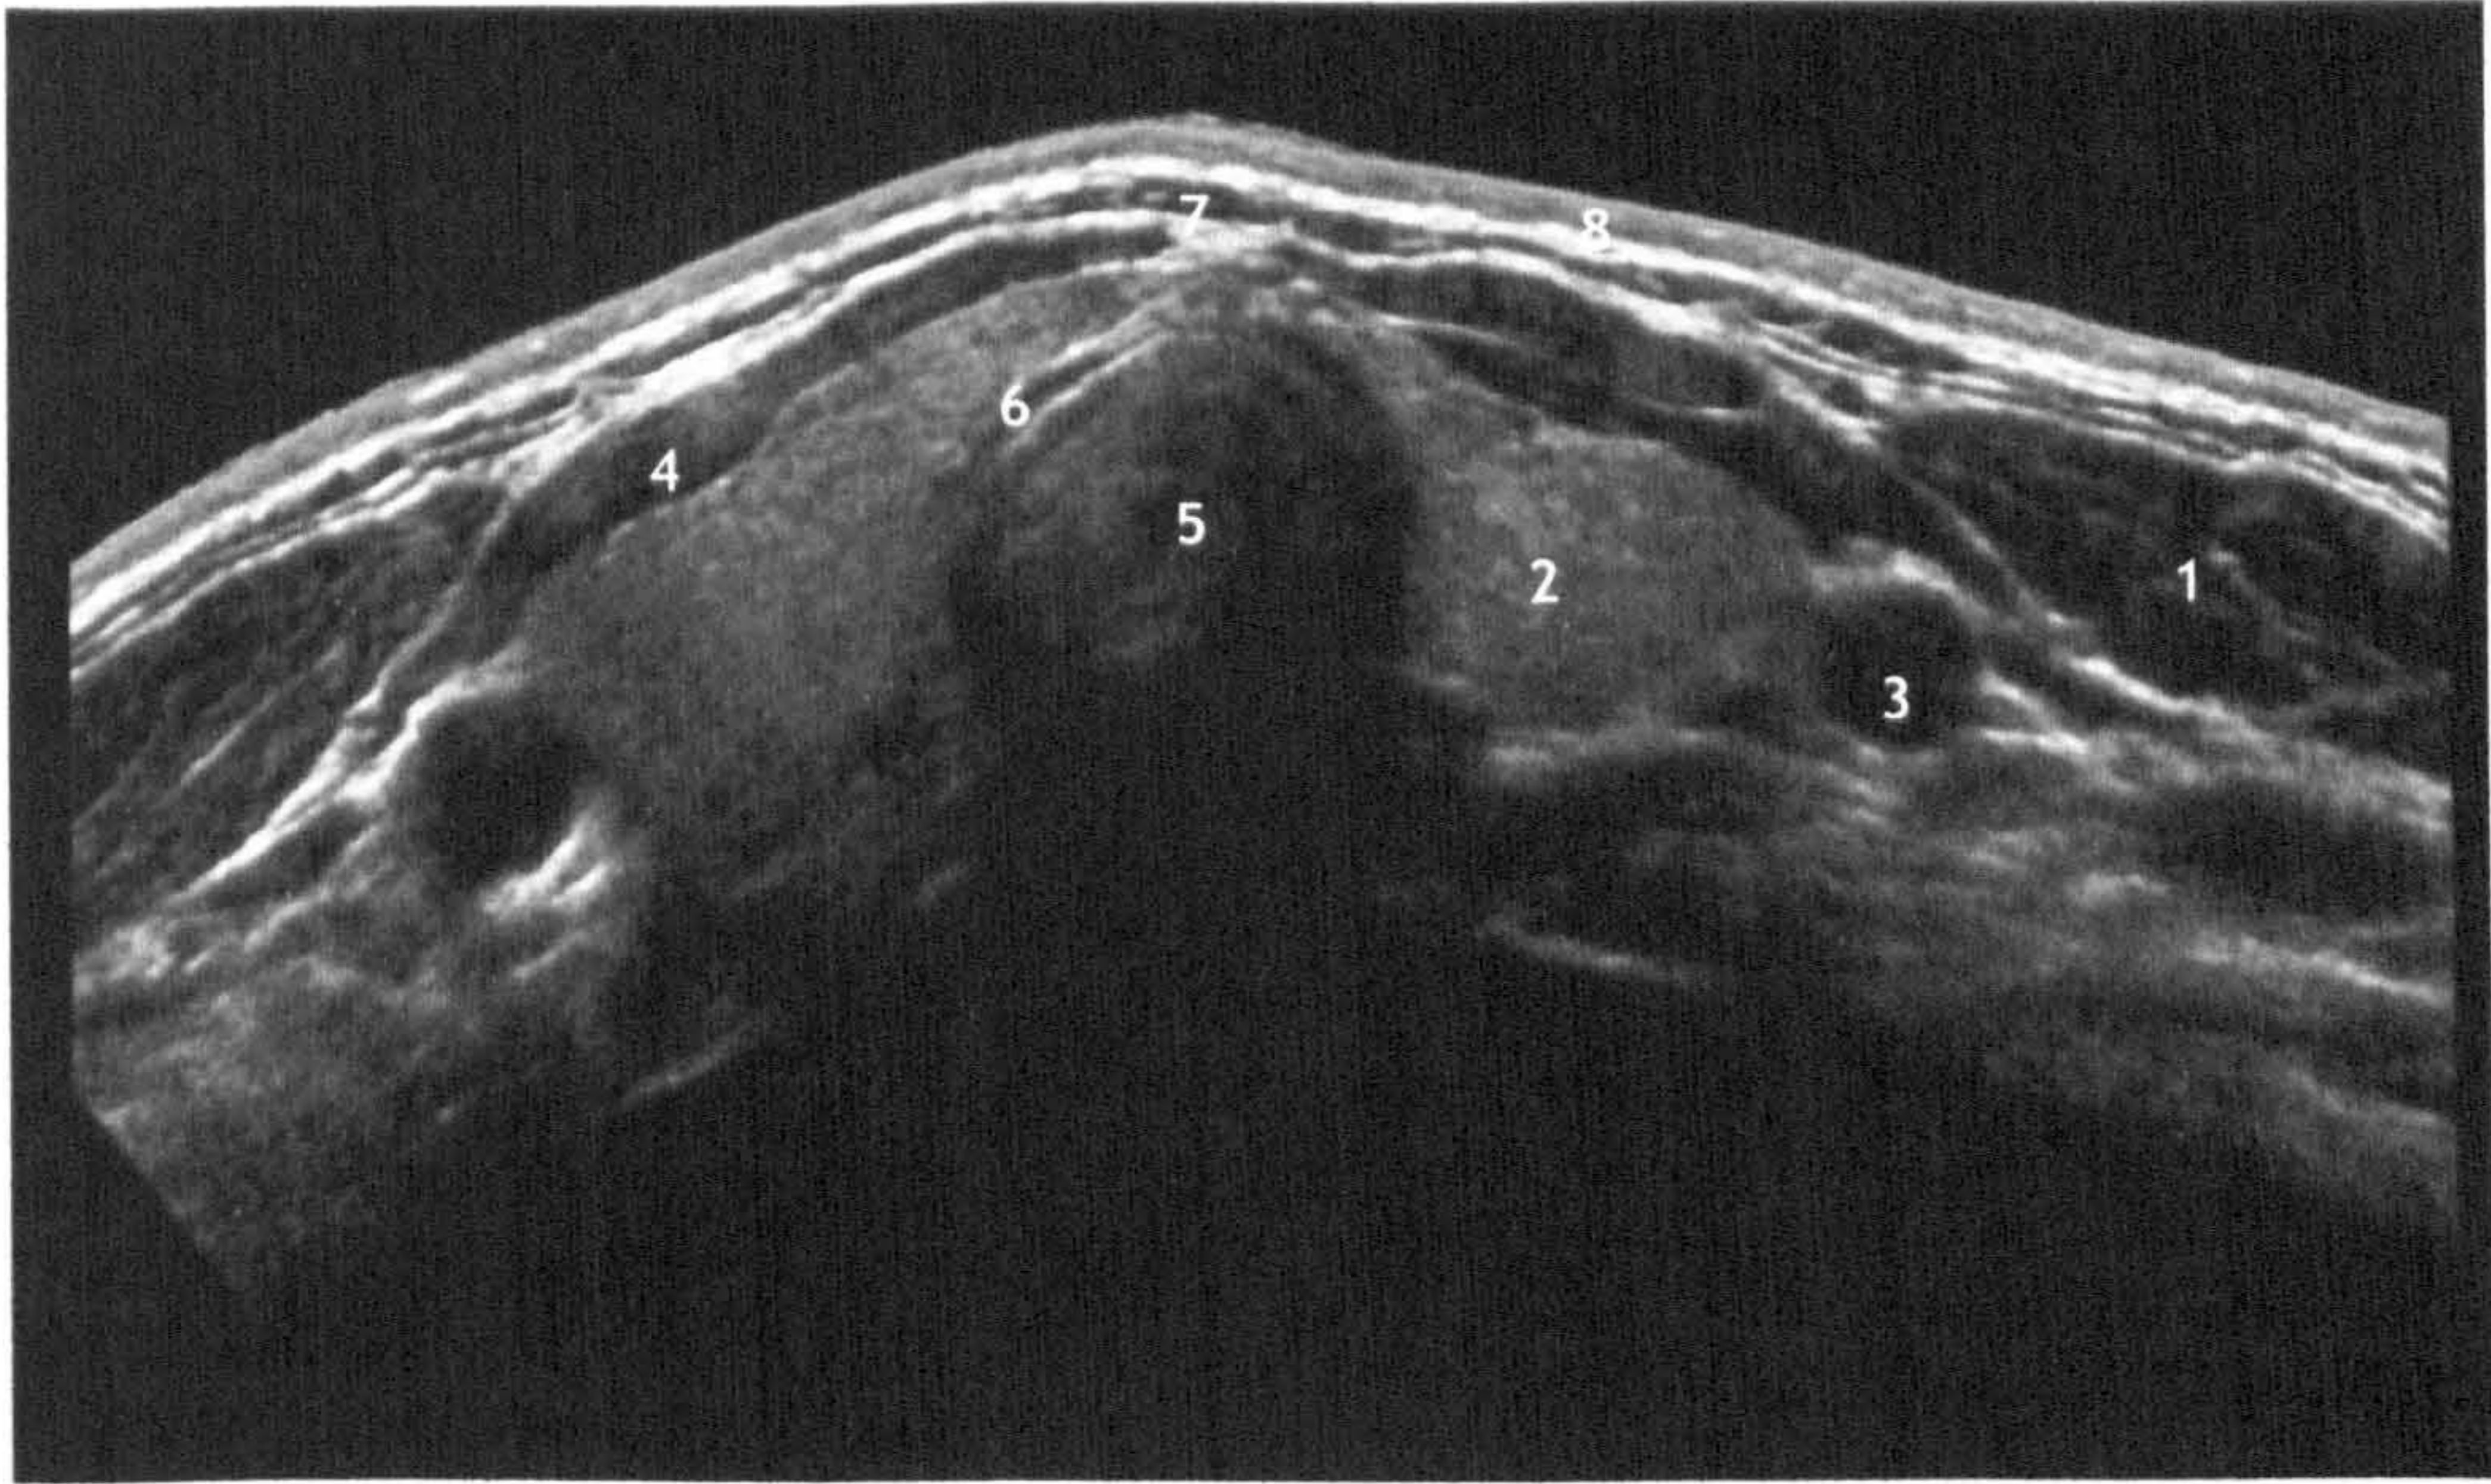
Ultrasound of the anterior neck
